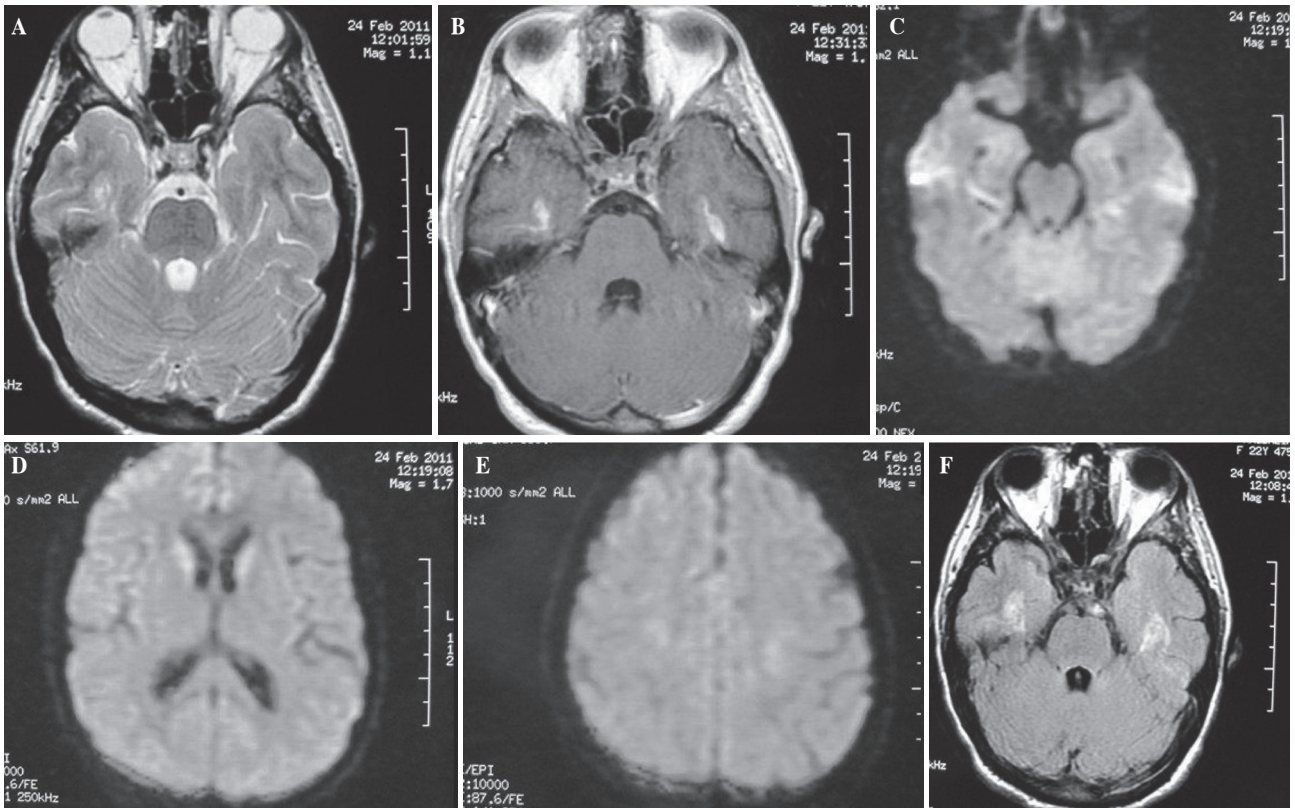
MRI findings after 13 days of hospitalization. (A) Axial T2-weighted MR image and (B) FLAIR image : demonstrate 13 days later absence of hyperintensity. (C) Axial DWI shows not restricted diffusion in the temporal lobes and right occipital lobe, (D) in the right occipital lobe and splenium and (E) in the centrum semiovale. (F) Contrast-enhanced axial T1W image demonstrates a reduction of the enhancement in the temporal lobes.
